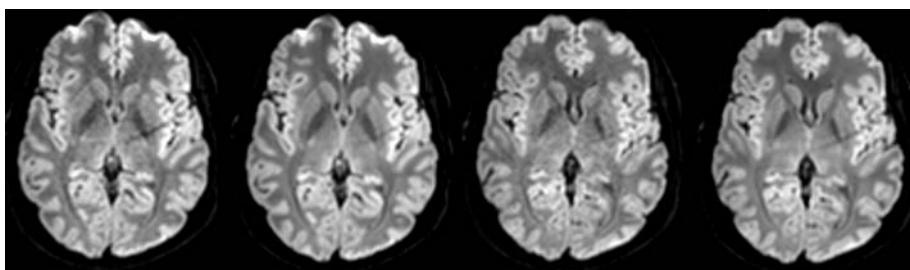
DWI isotropic images acquired in 32 directions. From left to right: Default DWI iso image without diffusion registration being used. Postprocessed DWI iso map without diffusion registration being used. Default DWI iso image with diffusion registration being used. Postprocessed DWI iso map with diffusion registration being used.
